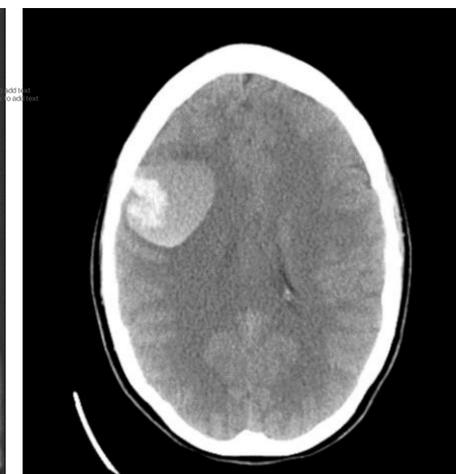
CT brain without contrast shows 4.2 cm hematoma in the right frontal lobe with no midline shift.
